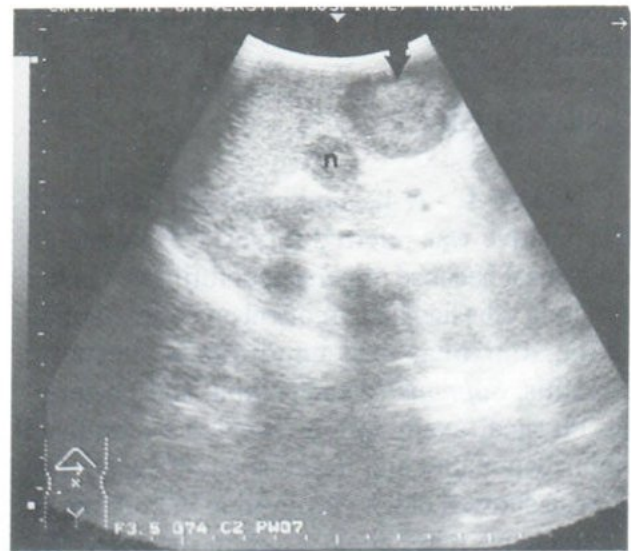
Transverse sonogram shows a "target" lesion (arrow) in caudate lobe of liver. Note enlarged lymph node (N) adjacent to the head of pancreas.
